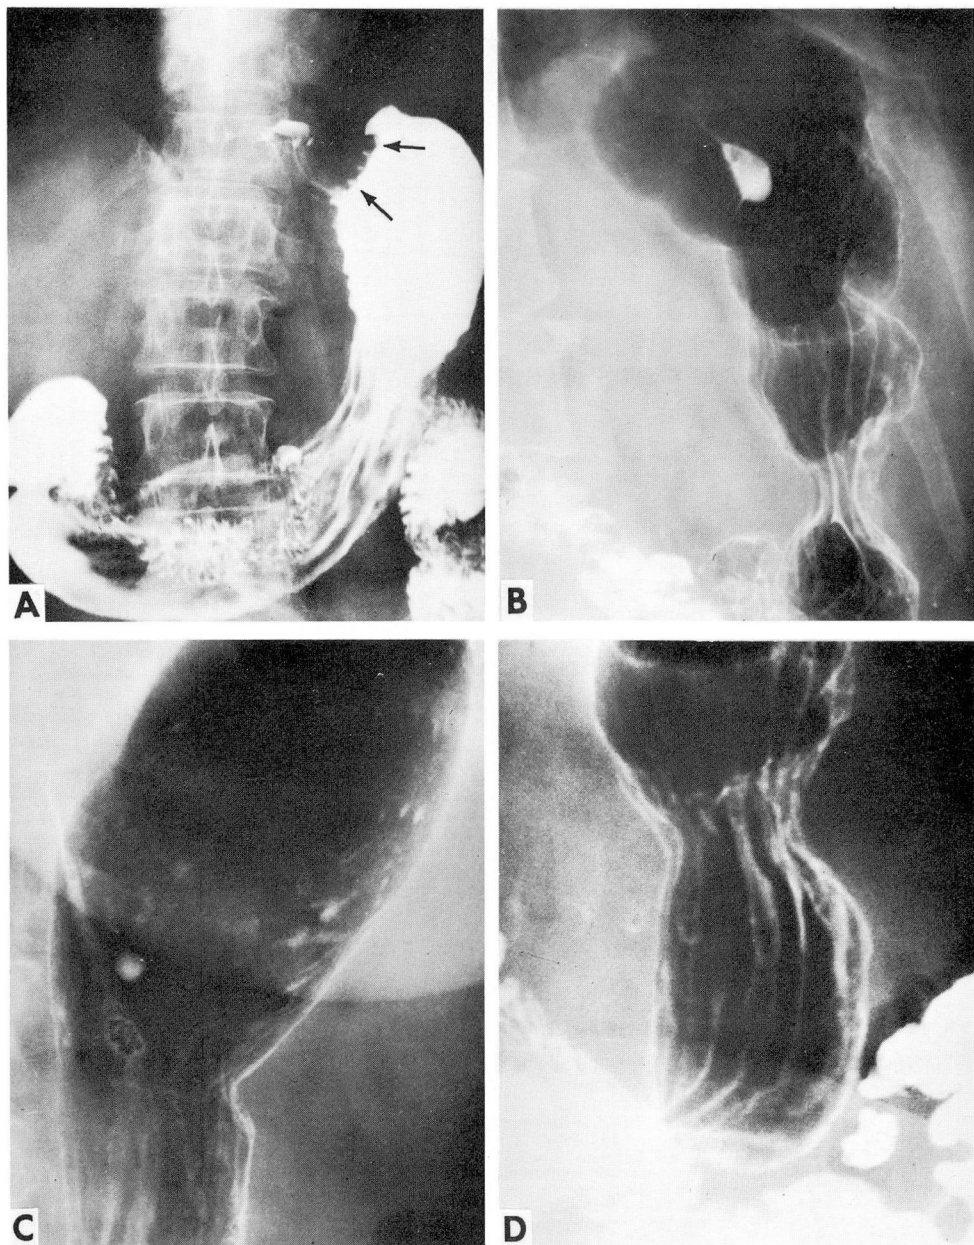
A, Anteroposterior roentgenograms, after conventional barium swallow, showing a suspicious deformity (arrows) in the cardia and fundus of the stomach. B, Barium-spray study of the stomach, showing a normal mucosal pattern with no evidence of tumor. C, Spot view of fundus shows no deformity. D, Spray study of the body of the stomach showing normal mucosal pattern in double contrast.
